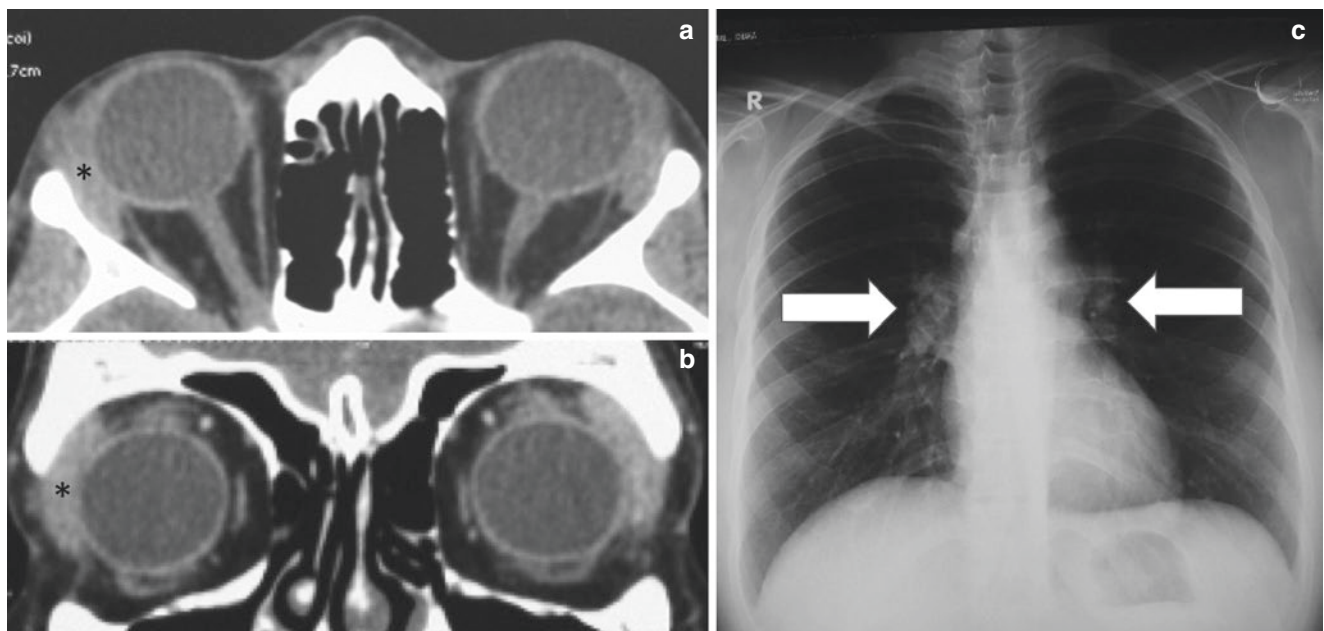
(a, b) Axial and coronal CT scan of the orbits showing bilateral hyperdense, enhanced, bulky lacrimal glands (*) partly wrapped around the globe. (c) Frontal chest x-ray showing bilateral hilar lymphadenopathy (arrows)
